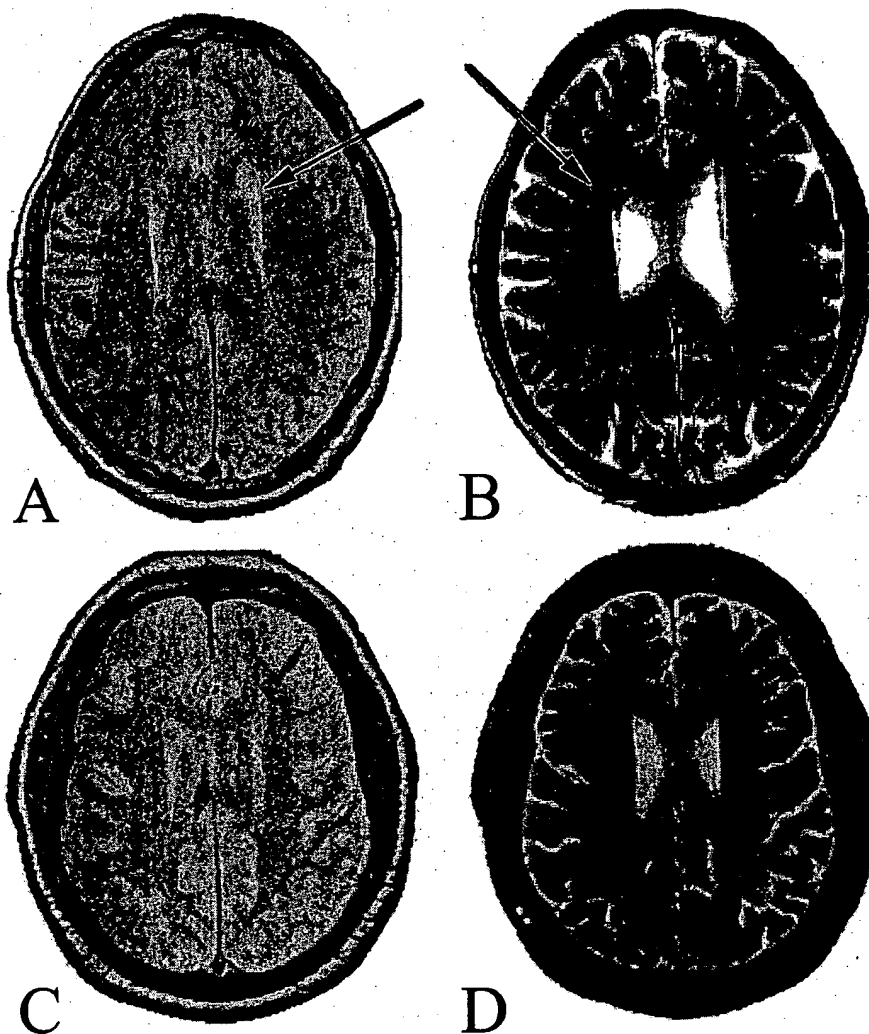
Axial images of carbon monoxide (CO)-poisoned patients (A,B) and matched control subjects (C,D): proton density (A,C) and T2-weighted (B,D) images. The arrow in A shows a representative periventricular white matter hyperintensity; the arrow in B shows a representative centrum semiovale white matter hyperintensity in a CO-poisoned subject.
